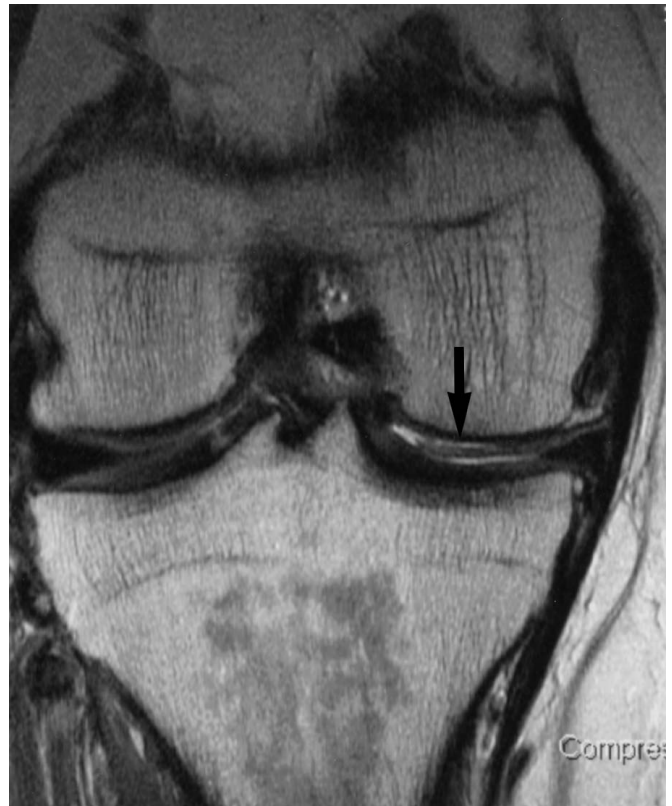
A coronal MRI scan of a 40-year-old man, obtained 7 months after autologous cartilage implantation, shows partial delamination of a transplant (arrow) over the medial femoral condyle with an articular flap and joint fluid extending between the transplant and the subchondral bone.
